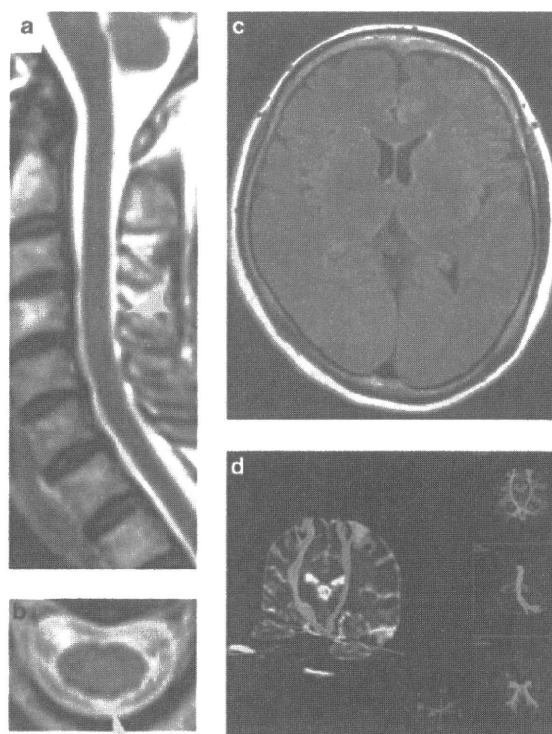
MRI of a 56-year-old female SMON patient. (a) T2-weighted image of the cervical spinal cord shows a longitudinal, faint hyperintensity in the sagittal image (arrowhead), (b) which was located on the dorsal column of the spinal cord in the axial image (arrowhead). (c) Brain MRI FLAIR image appears normal. (d) MR tractography shows normal tracing of the pyramidal tract above the brain stem.
